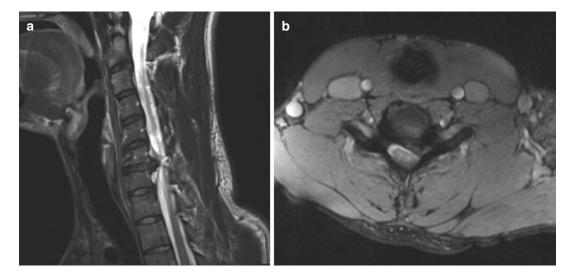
(a) Sagittal and (b) axial T2-weighted magnetic resonance imaging (MRI) of the left foramina
